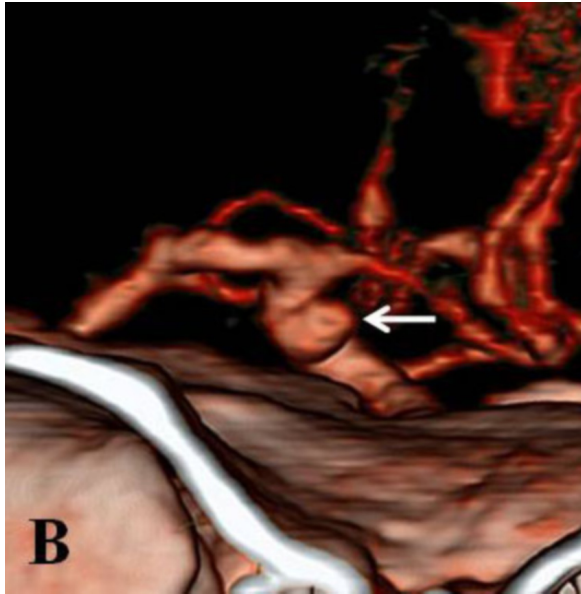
63-year-old female with anterior-wall aneurysm of the ICA. 3D-CTA 14 days after the initial symptoms, just after the aneurysm re-ruptured, shows progression to a saccular type aneurysm (arrow), clearly demonstrable by angiography (arrow) (Fig. 1C).
